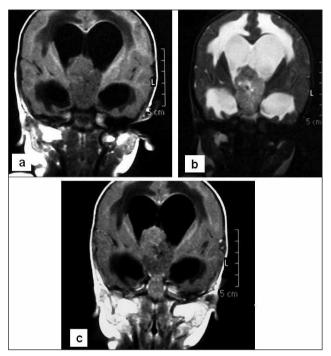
12-month-old girl with suprasellar AT/RT (Case-2). A, coronal T1-weighted and, B, coronal T2-weighted MR images showing a large mass containing small central necrotic areas and, predominantly isointense with gray matter. There is intraventricular extension causing obstructive hydrocephalus and resultant periventricular edema. C, Post-contrast coronal T1-weighted MR image showing patchy tumor enhancement.
